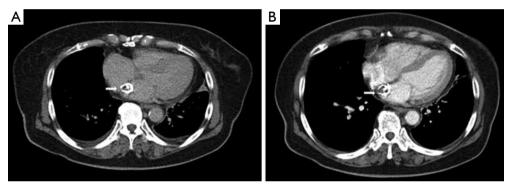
Chest computed tomography demonstrating approximately 2 cm-sized, calcified mass in the left atrium which was attached to the interatrial septum. (A) Non-enhanced image; (B) enhanced image.
